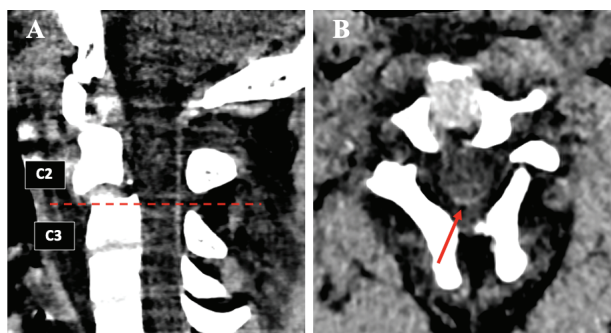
Cervical CT Scan sagittal view (A) and axial view (B) of the C2 and C3 cervical spine. There is hematomyelia in the level of C2 and C3 (arrow).
